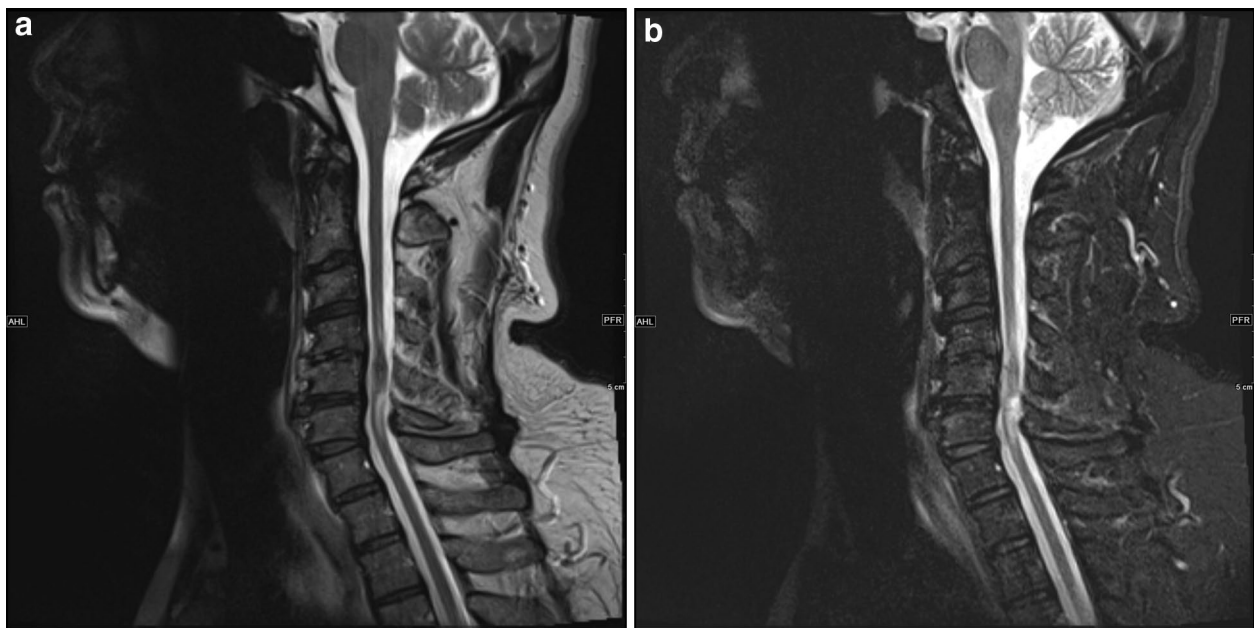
Sagittal T2 MRI (a) and sagittal STIR (b) of the cervical spinal cord shows heterogeneous signal intensity with surrounding edema at C4–C5.
